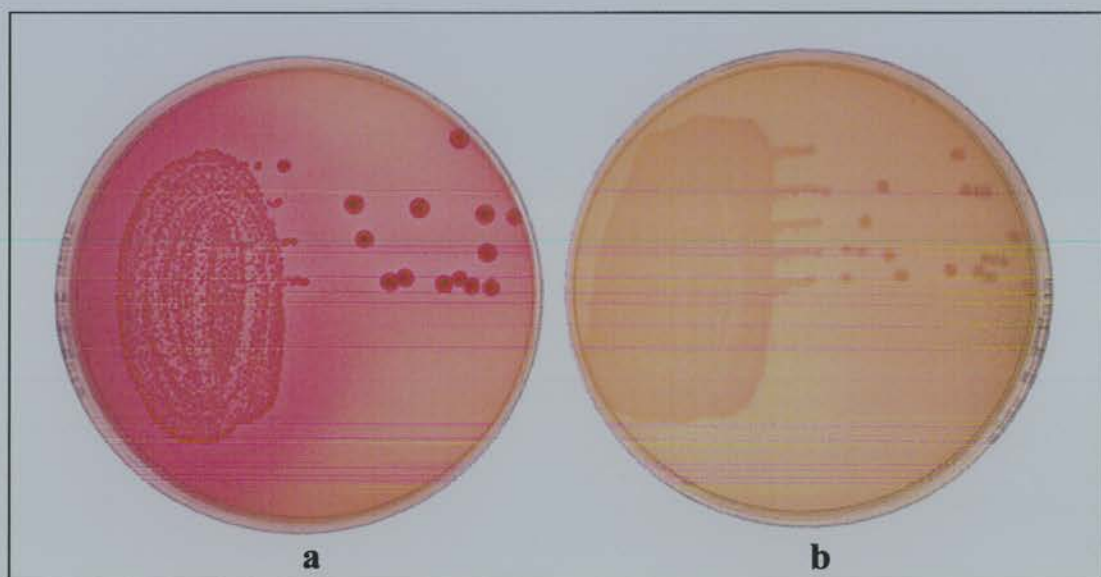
a) The donor lactose-fermenting *Escherichia coli* CT 73 and b) the recipient non-lactose-fermenting *Escherichia coli* J62-2 growing on MacConkey agar.
